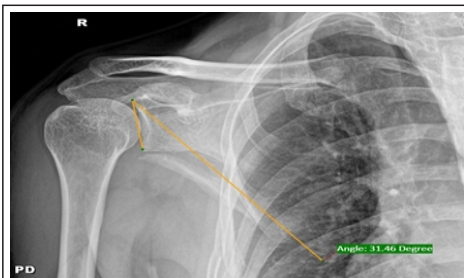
Glenopolar angle measured on X-rays.
